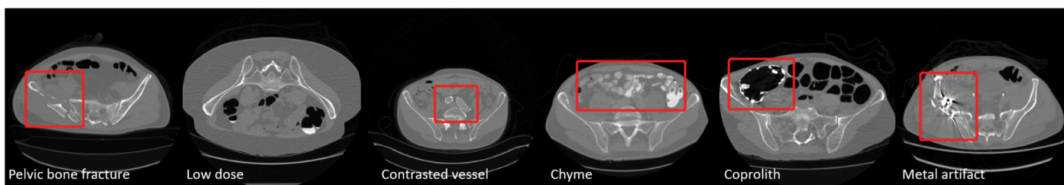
CTSpine1K CT image examples with various conditions
